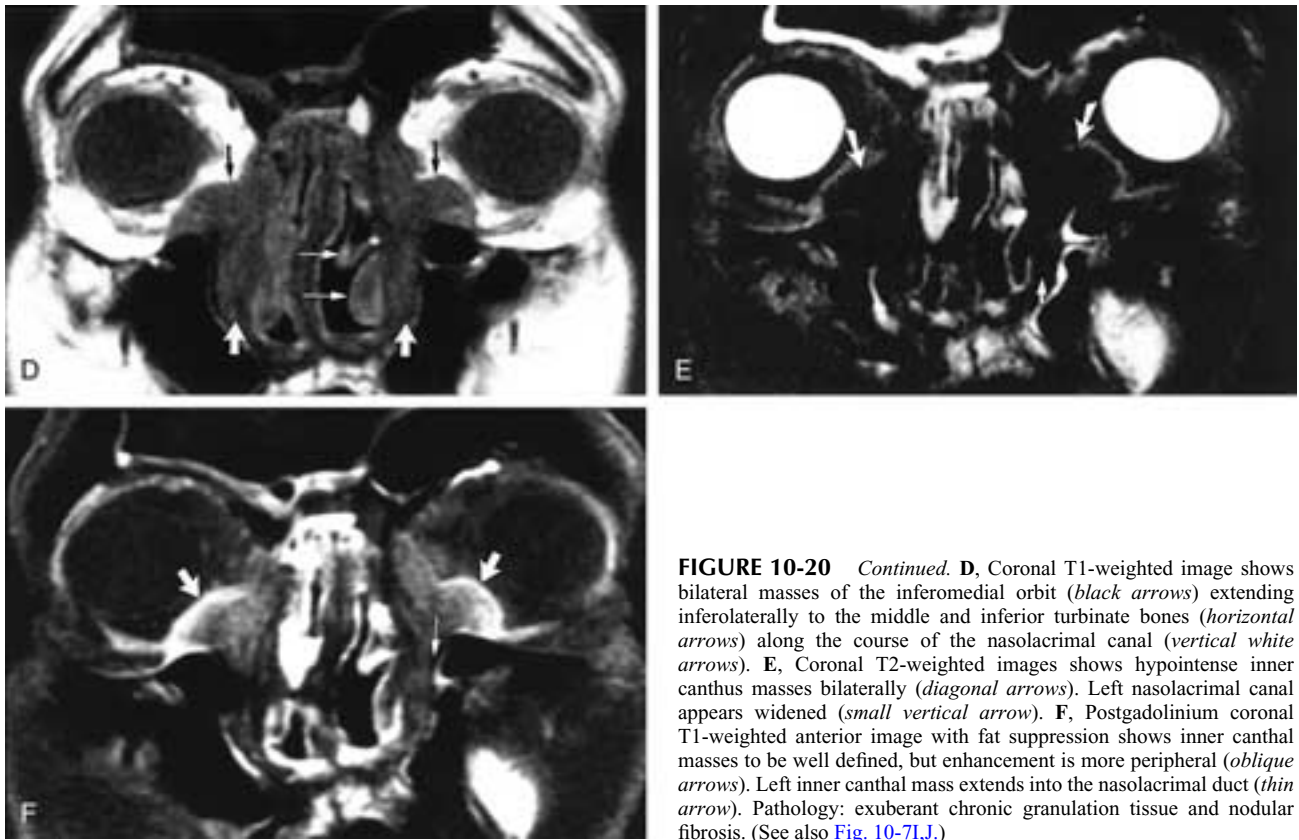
Continued.* D, Coronal T1-weighted image shows bilateral masses of the inferomedial orbit (*black arrows*) extending inferolaterally to the middle and inferior turbinate bones (*horizontal white arrows*) along the course of the nasolacrimal canal (*vertical white arrows*). E, Coronal T2-weighted images shows hypointense inner canthus masses bilaterally (*diagonal arrows*). Left nasolacrimal canal appears widened (*small vertical arrow*). F, Postgadolinium coronal T1-weighted anterior image with fat suppression shows inner canthal masses to be well defined, but enhancement is more peripheral (*oblique arrows*). Left inner canthal mass extends into the nasolacrimal duct (*thin arrow*). Pathology: exuberant chronic granulation tissue and nodular fibrosis. (See also [Fig. 10-71,J](#).)
